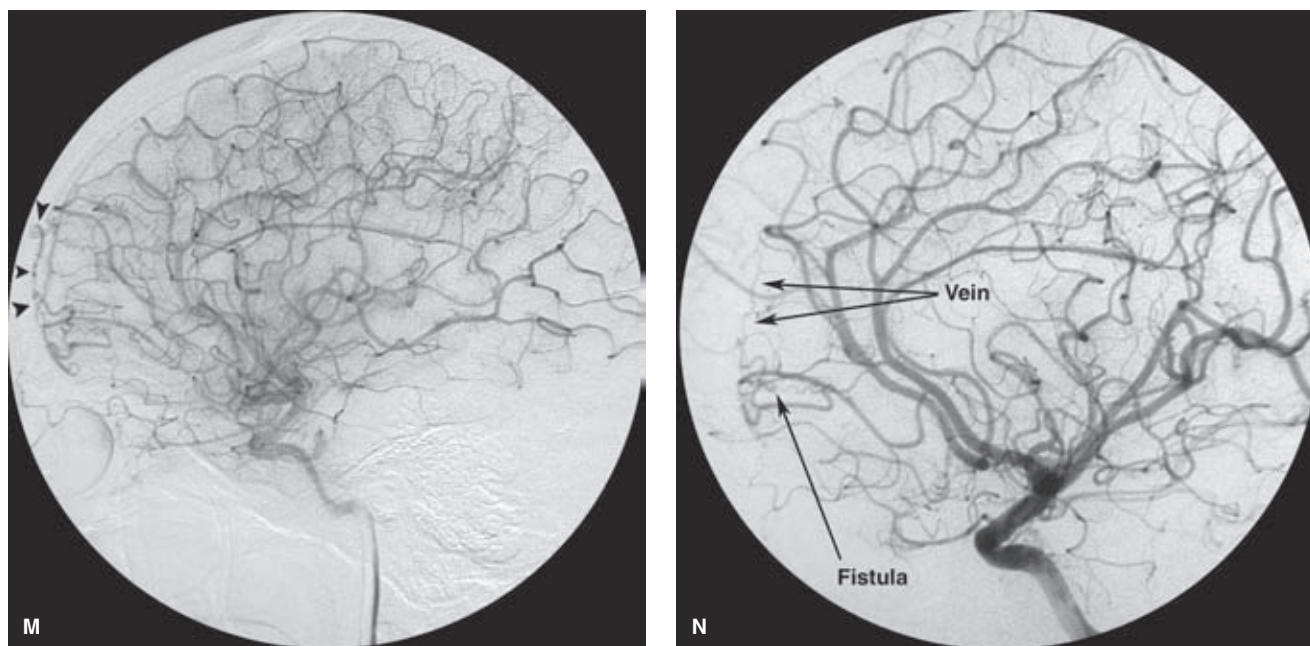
(CONTINUED) Case 4. M–N: A 33-year-old female was admitted with nausea, vomiting, and visual disturbances. A CT and MRI (not shown) demonstrated a moderate-sized left frontal intraparenchymal hemorrhage. The left internal carotid artery injection shows a subtle tangle of vessels in the late arterial phase (*arrowheads in M*) with subsequent early opacification of the superior sagittal sinus. The magnification oblique view demonstrates the precise fistula to better advantage (*N*).
